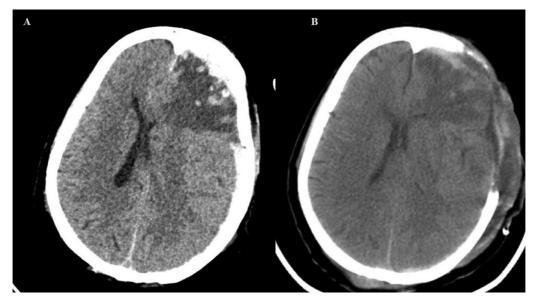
Non-contrast CT head showing (A) left FTP SDH with a midline shift of 1.1 cm with left frontotemporal contusion who underwent (B) left FTP DC.
